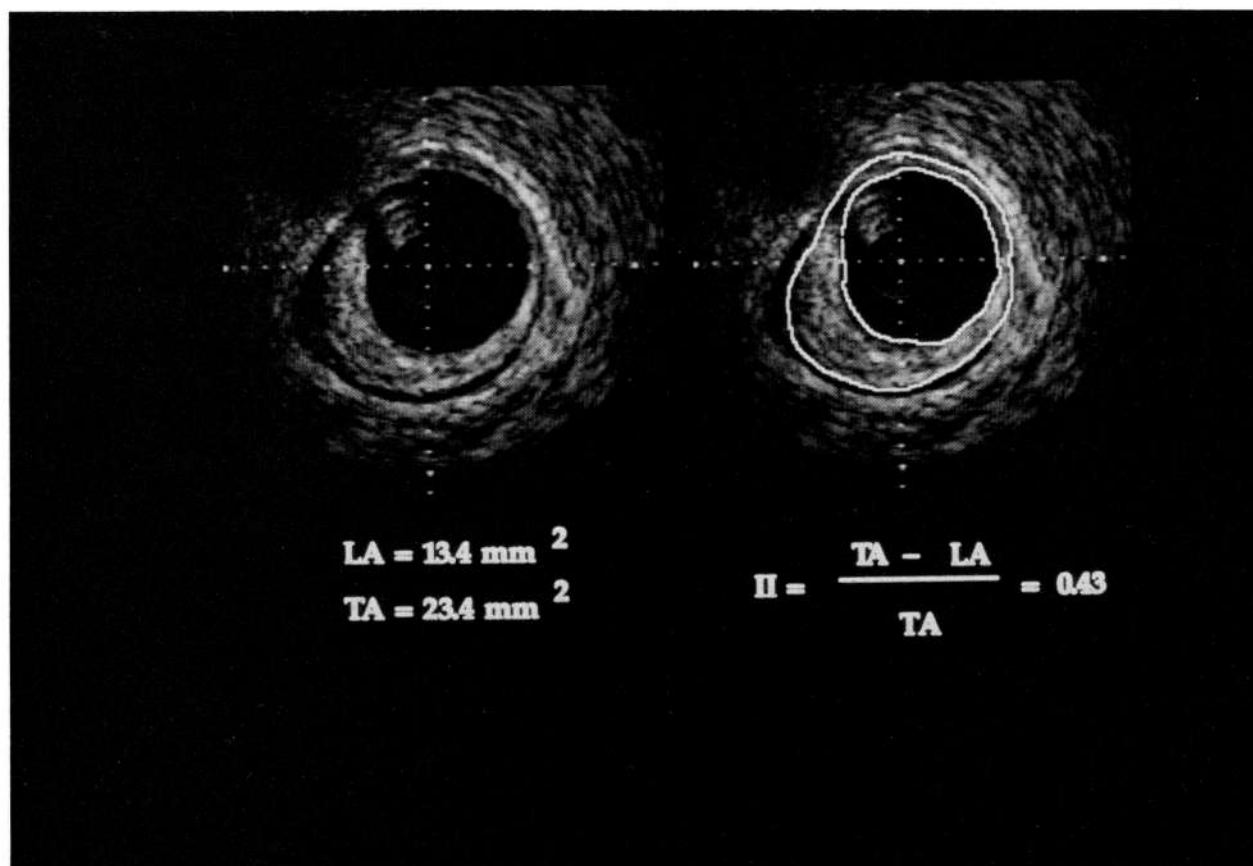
Intracoronary ultrasound image obtained in a patient 7 years after transplantation, showing three-layer appearance of vessel wall. Right panel shows the method of determining the index of intimal thickening (II). LA, luminal area; TA, total area. Perpendicular grid of tick marks are at 0.5-mm intervals. Bright shadow at 11 o'clock position at the edge of the catheter is an artifact caused by mechanical strut and coronary guide wire.
